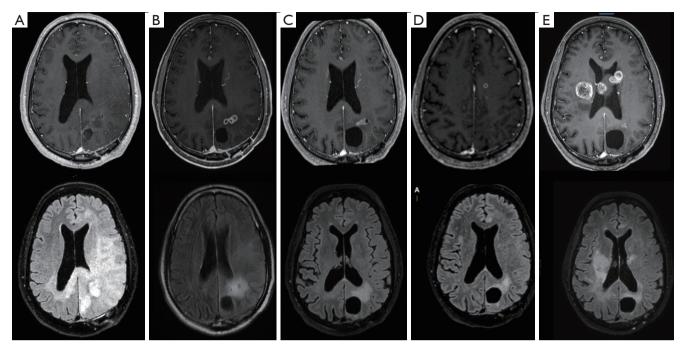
MRI scans of the patient. (A) Postoperative/pre-radiation MRI. Top: T1 post-contrast sequence showing surgical cavity and cluster of small enhancing lesions anteriorly (arrow). Bottom: FLAIR sequence showing diffuse FLAIR abnormality consistent with GC. (B) MRI 3 weeks after finishing radiation treatment. Top: mild enlargement of cluster of small enhancing lesions anteriorly, consistent with post-radiation change (arrow). Bottom: significant resolution of GC change. (C) MRI 8 months after finishing surgery. Top: stable enhancing lesions. Bottom: persistent significant resolution of GC change. (D) MRI 11 months after surgery. Top: new enhancing lesion (arrow), consistent with progression. Bottom: persistent significant resolution of GC change. (E) MRI 13 months after surgery. Top: significant progression of disease with multiple new enhancing lesions in splenium of corpus callosum crossing the midline to the right, left ventricular margin of occipital horn, genu of corpus callosum, and left frontoparietal area. Bottom: prior GC changes remain in response. New FLAIR abnormality due to progression. MRI, magnetic resonance imaging; FLAIR, fluid attenuated inversion recovery; GC, gliomatosis cerebri.
